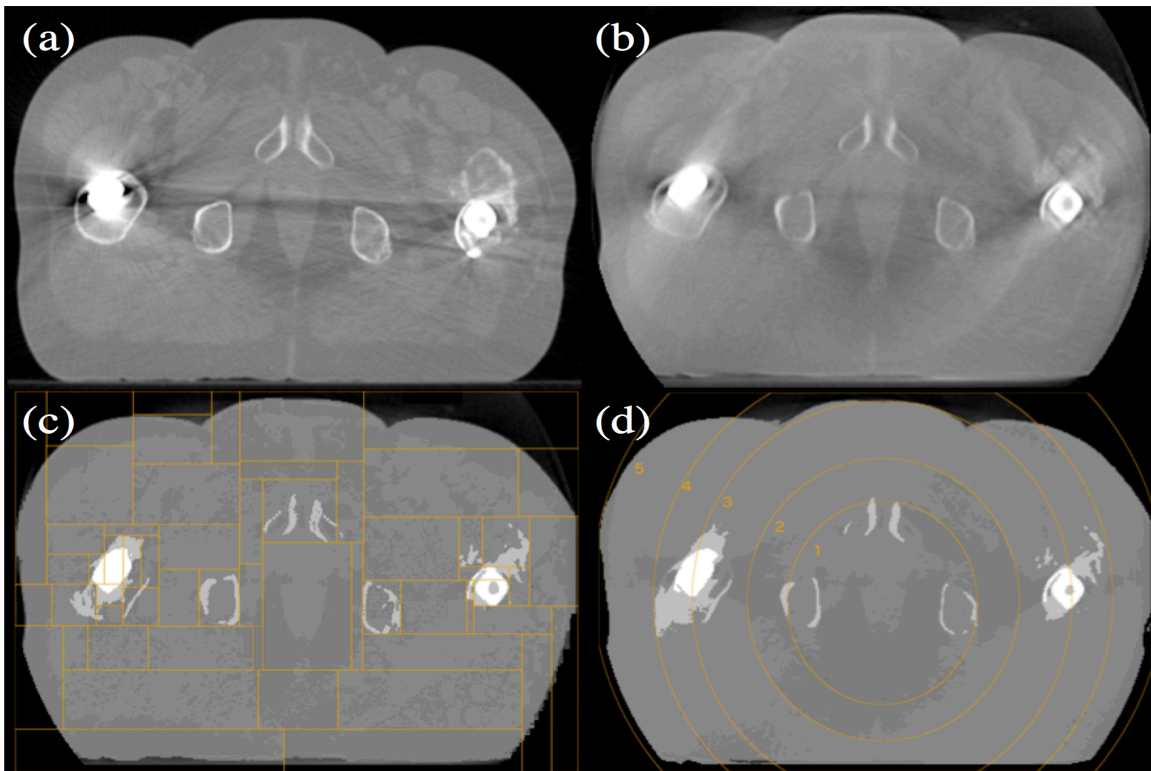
A slice of the pCT (a) and the original CBCT (b) and the resultant images after segmentation CBCT using the manual MLT (sCBCT_{man}) and the automated MLT (sCBCT_{auto}) (c and d respectively).
